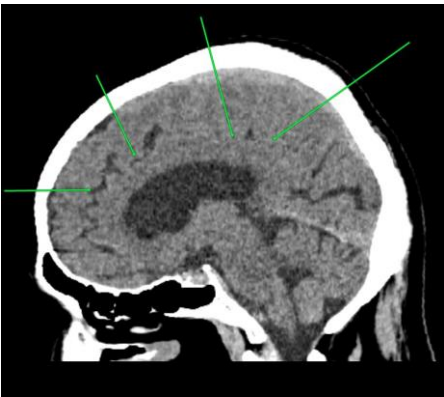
Green arrows show half of cingulate sulcus narrower than the anterior half in a sagittal CT scan.
